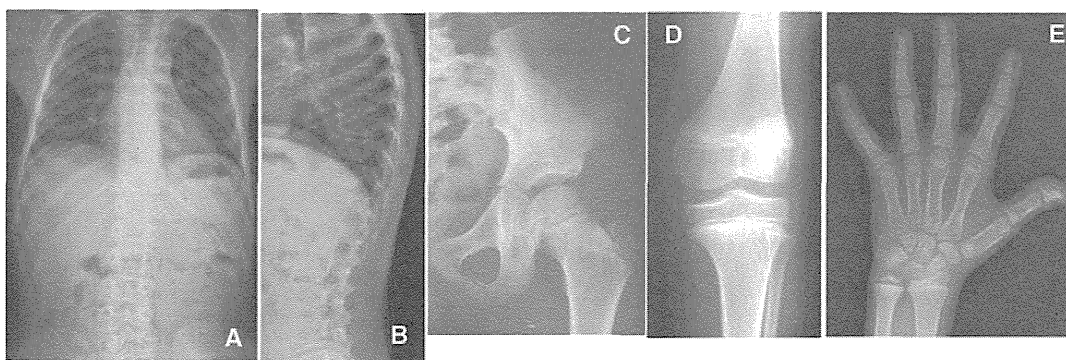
Radiographs of P1 (III-2 in family 1) at age 8.5 years. (A) Spine anteroposterior (AP). Mildly overfaced vertebra. (B) Lateral spine. Mild flattening of vertebral bodies and irregular endplates. (C) Left hip AP. Almost normal epiphysis. (D) Left knee AP. Epiphyseal and metaphyseal abnormalities are unremarkable. (E) Left hand AP. Metacarpals are mildly shortened with mild irregularity of the growth plates. Epiphyses of the distal radius and ulna show mild dysplasia. The bone age is advanced.
